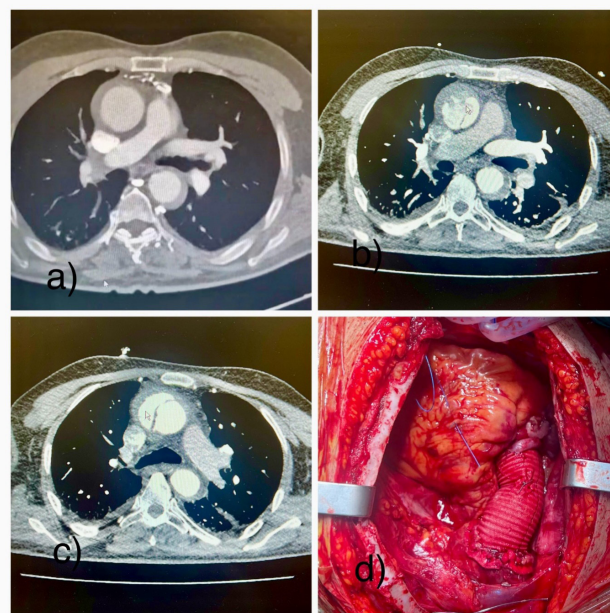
Preoperative CT views and intraoperative view
